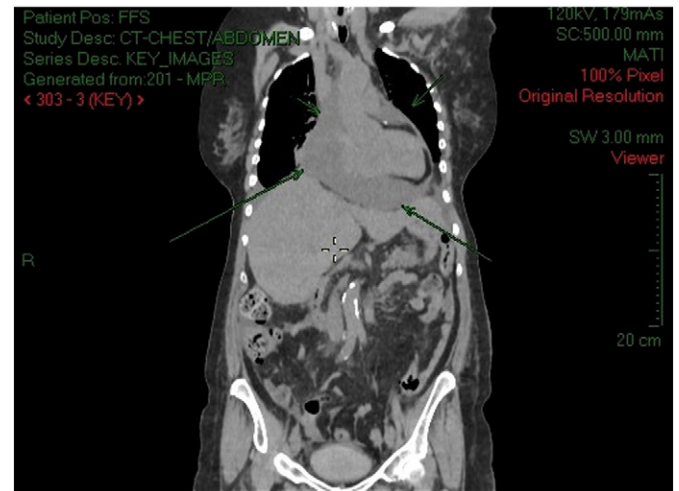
CT coronal view demonstrating the large pericardial effusion (arrows), note the relative paucity of ascitic fluid.
